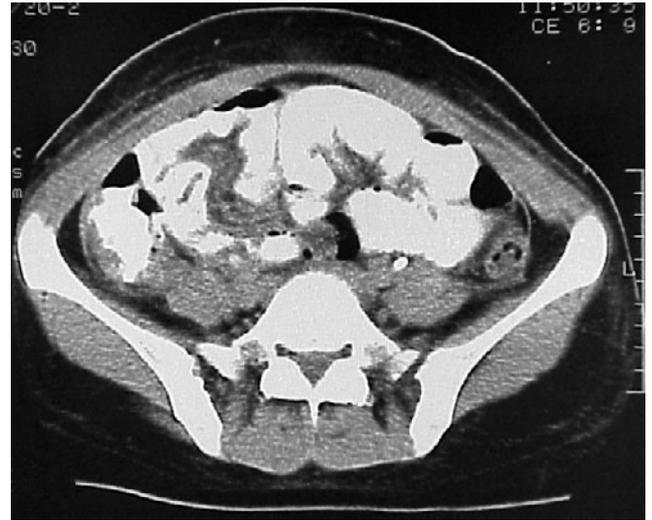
Abdominal CT scan in patient 2 shows concentric mural thickening of terminal ileal loops together with luminal dilatation in proximal loops. Pneumatosis intestinalis is also evident.
